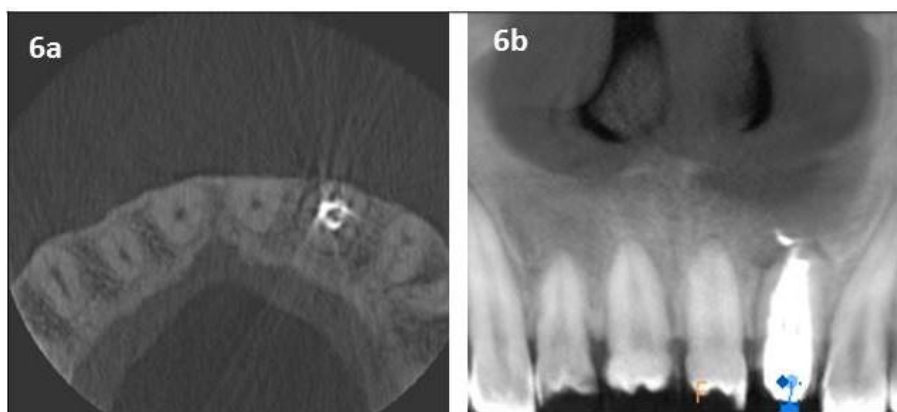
Post-operative CBCT axial and sagittal view
